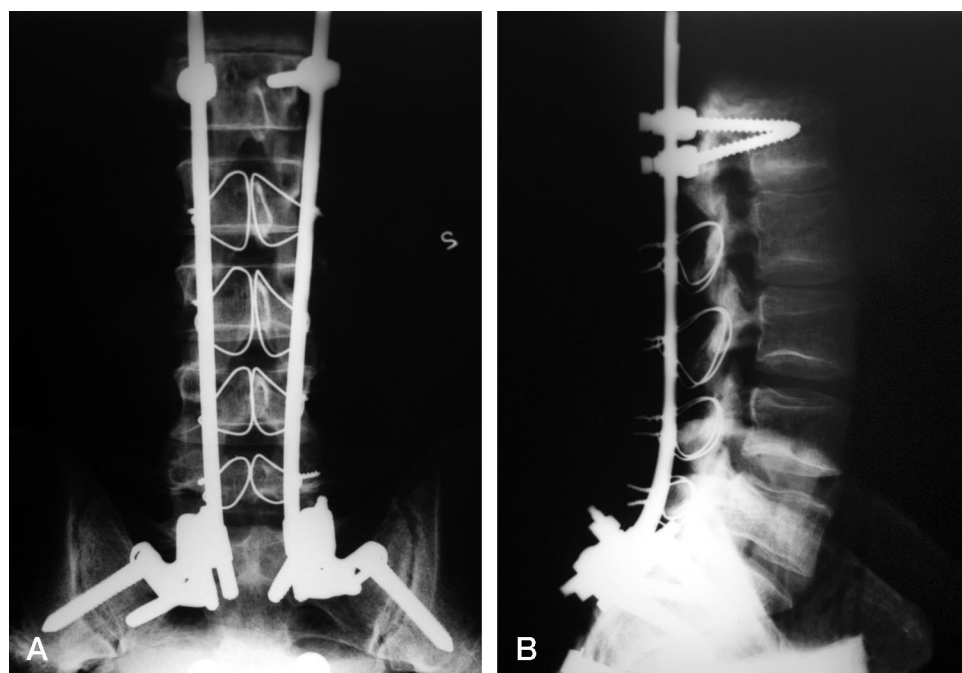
Anteroposterior (A) and lateral (B) radiographs of a Colorado II sacropelvic fixation.
